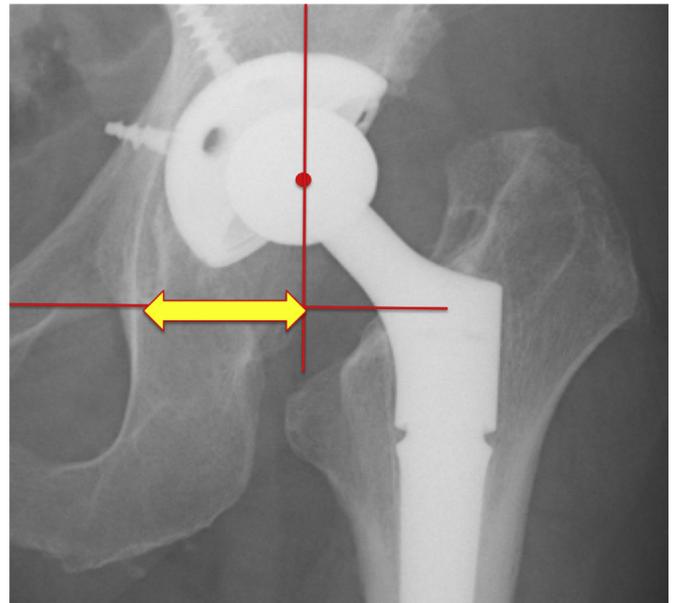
Horizontal distance from hip center to tip of teardrop. The horizontal red line in this radiograph is the interteardrop line; a vertical line has been drawn perpendicular to the interteardrop line. The horizontal distance between the tip of the teardrop and the hip center is denoted by the yellow arrow.
